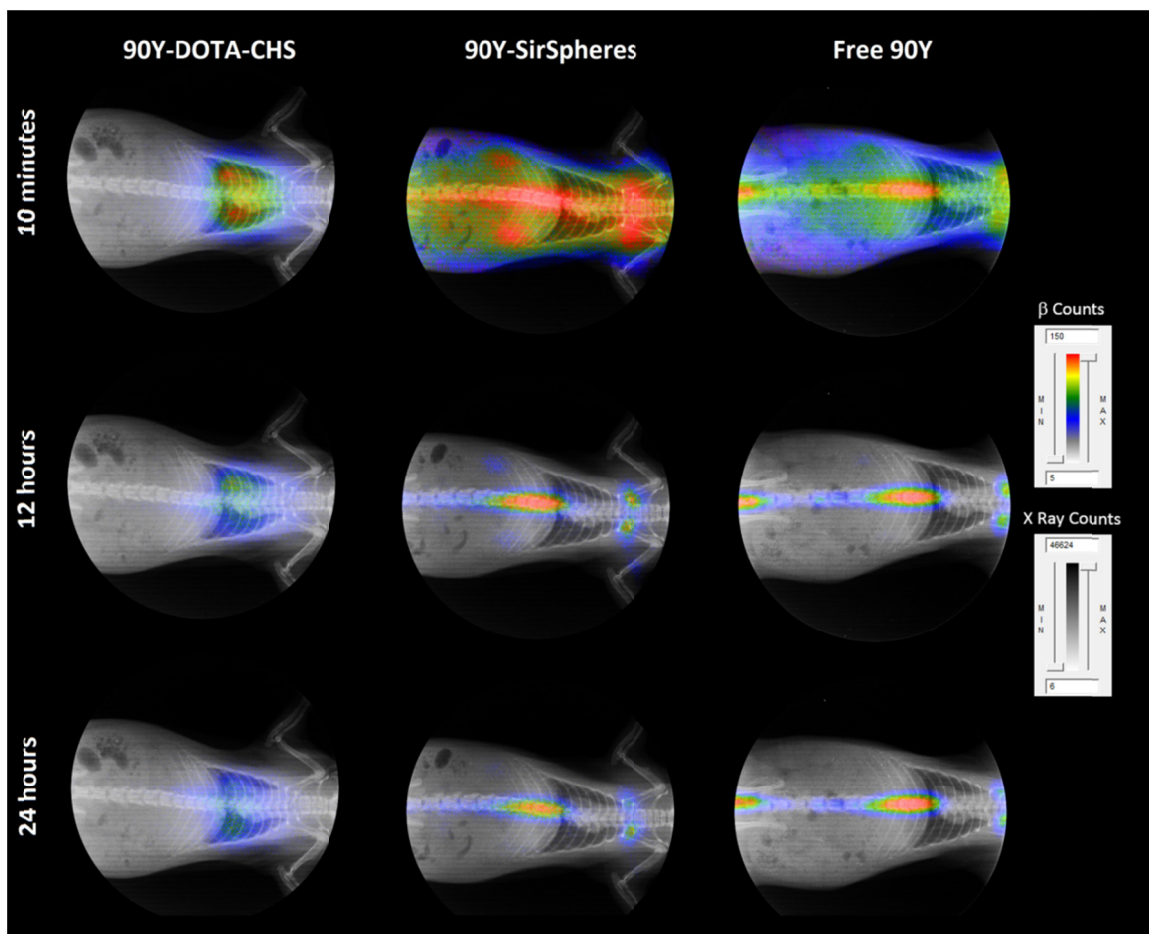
Non decay-corrected, un-collimated full body X-Ray/Autoradiography for ^{90}Y -DOTA-CHS, ^{90}Y -Resin and free ^{90}Y at 10 minutes, 12 and 24 hours.
